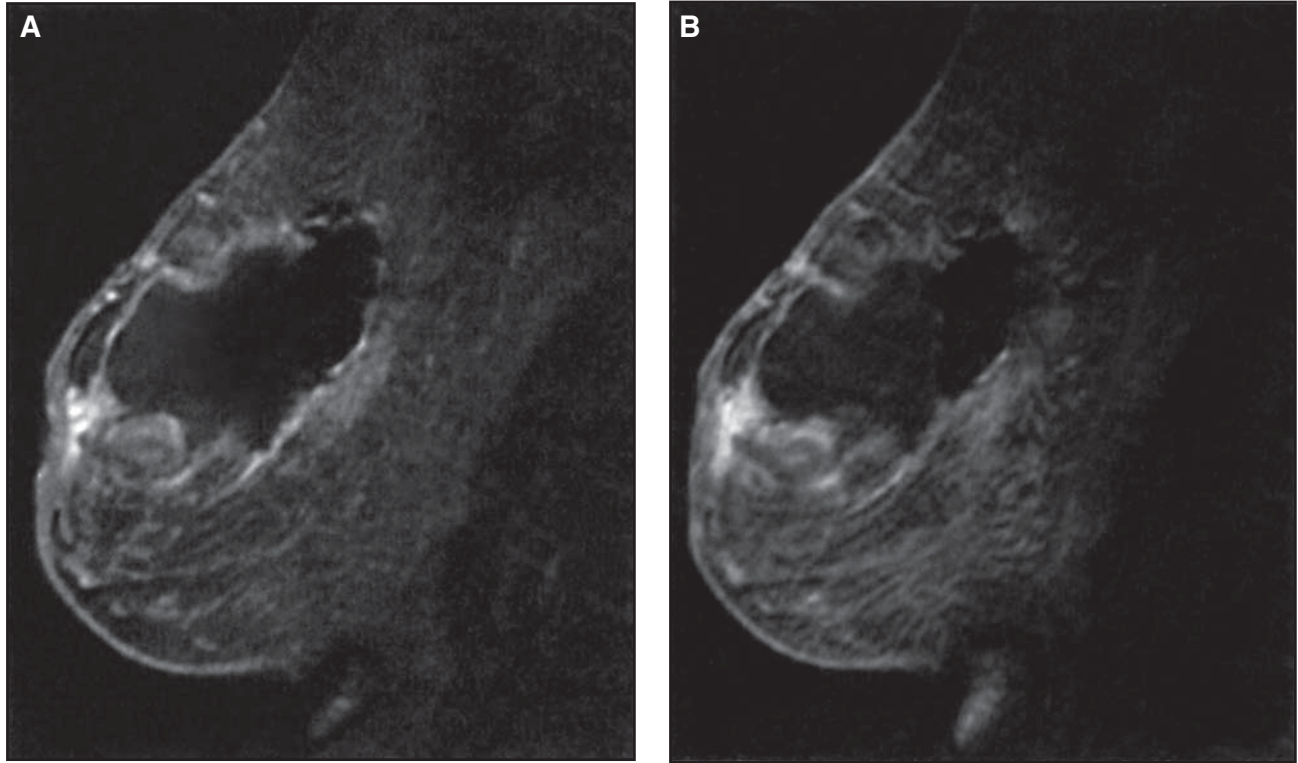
Sixty-four-year-old woman after left lumpectomy for invasive ductal carcinoma with positive surgical margins. A. Sagittal T1-weighted image from postoperative magnetic resonance (MR) of left breast immediately after contrast injection shows focal clumped enhancement in the anterior aspect of the seroma cavity. B. Delayed contrast-enhanced T1-weighted image from left breast MR shows clumped enhancement with persistent kinetics. Surgery revealed invasive ductal cancer at site. (Reprinted with permission from: Bartella L, Liberman L, Morris EA, Dershaw DD. Nonpalpable mammographically occult invasive breast cancers detected by MRI. *AJR Am J Roentgenol.* 2006;186(3):869.)
